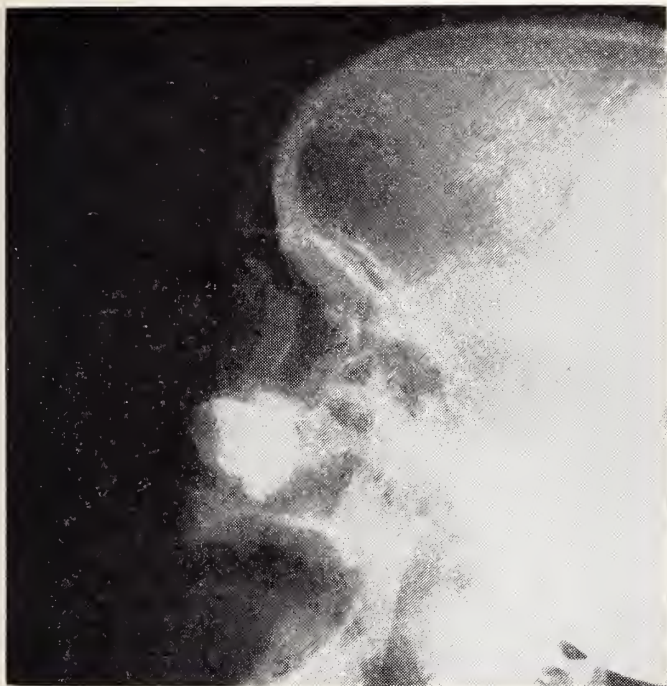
Lateral roentgenograms show large rhinolith in nasal cavity.
